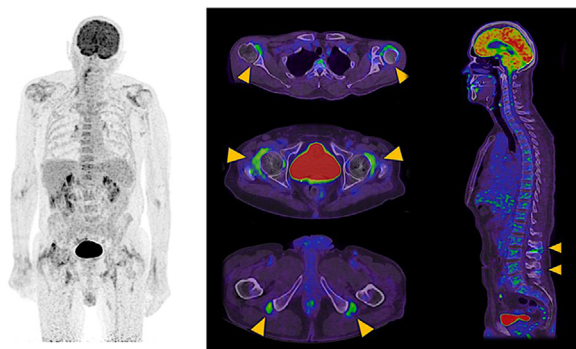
Typical [¹⁸F]FDG-PET uptake pattern observed in PMR: typical target sites of [¹⁸F]FDG-PET/CT uptake in PMR: shoulder, hips/trochanters, ischial tuberosities, interspinous bursae.
